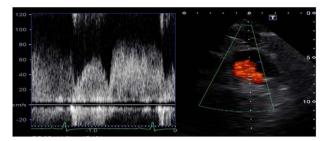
Pulsed-wave doppler echocardiography confirmed the left coronary wave pattern which peaked during diastole. These echocardiographic findings suggested BWGS.
